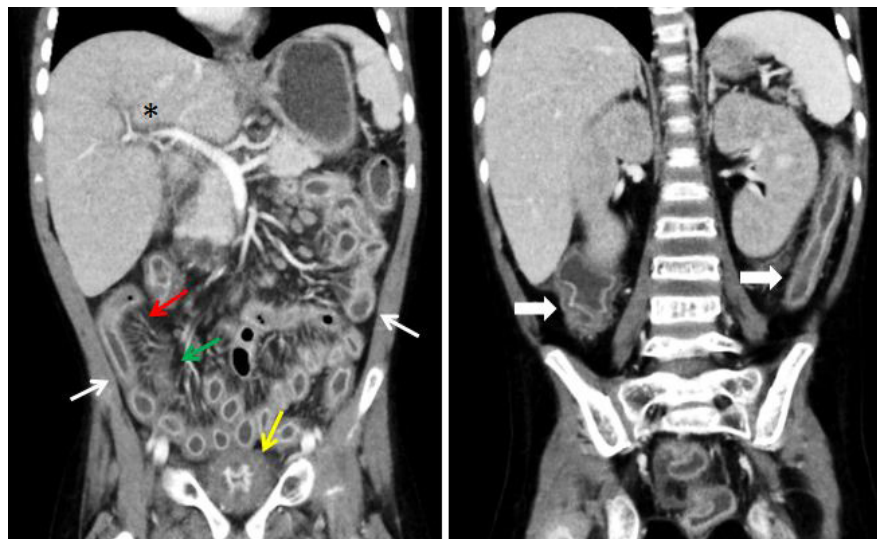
Coronal contrast-enhanced CT images of the abdomen and pelvis. There is diffuse mural thickening and excessive mucosal enhancement of the small (thin white arrows) and large bowel (thick white arrows), with associated engorgement of the vasa recta (red arrow) and mesenteric stranding (green arrow). The bowel is diffusely fluid filled, consistent with patient's history of diarrhea. There is diffuse mural thickening and mucosal hyperenhancement of the bladder (yellow arrow). Patient has known BK virus-associated hemorrhagic cystitis.
